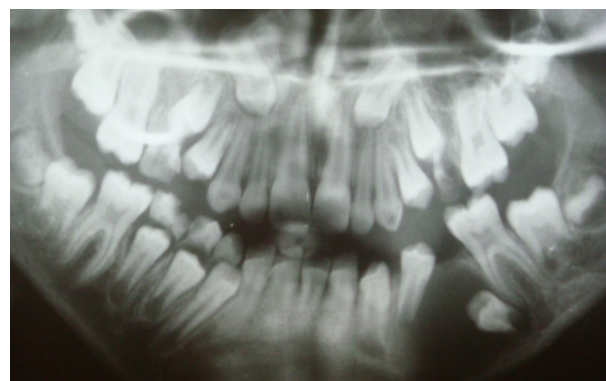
Panoramic radiograph taken four months after extraction of mandibular left primary second molar
